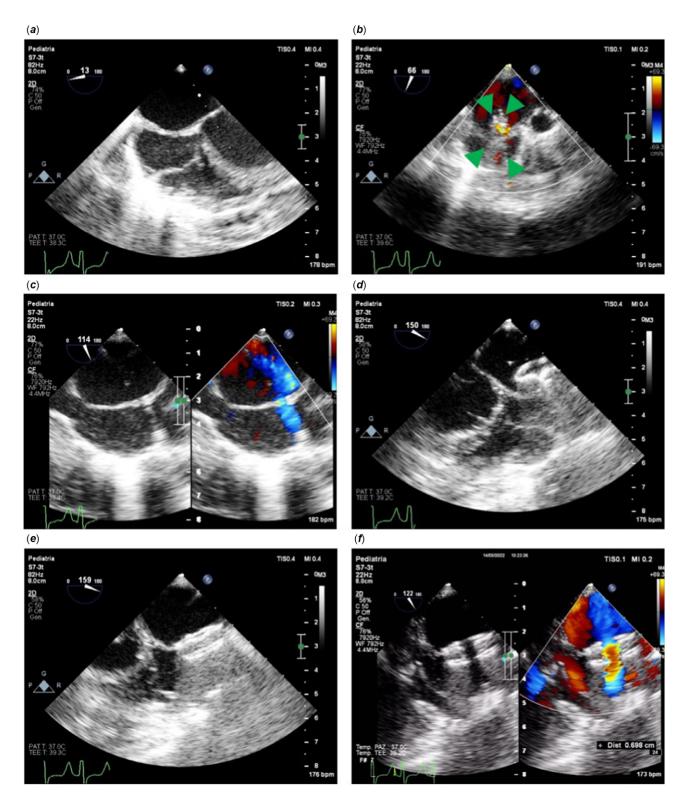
Hybrid approach for AFR implantation in 6-month-old infant. (*a*) Atrial septum from a transverse view. The total septal length was 30 mm. (*b*) The atrial septum was punctured with a 18 Ga, than stabilised a SV5 guidewire in the left atrium. On the guidewire, an 8x20 mm Sterling balloon was inflated (green arrows). (*c*) After the inflation, a 4 mm atrial septal defect was obtained. (*d*) An 11 Fr Terumo sheath was advanced in the atrial septal defect, and the left disk was deployed in the dilated left atrium. (*e*) By keeping a gentle traction on the system, the right disk was opened. Once verified the device stability, the device was deployed. (*f*) Color-Doppler demonstrated the left to right shunt. The diameter was 7 mm.
